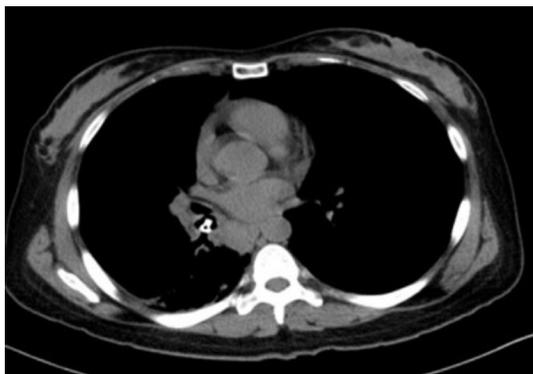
CT scan thorax in axial plane in non-contrast soft tissue window shows a calcified foreign body within the right bronchus intermedius with similar density to the bones.
